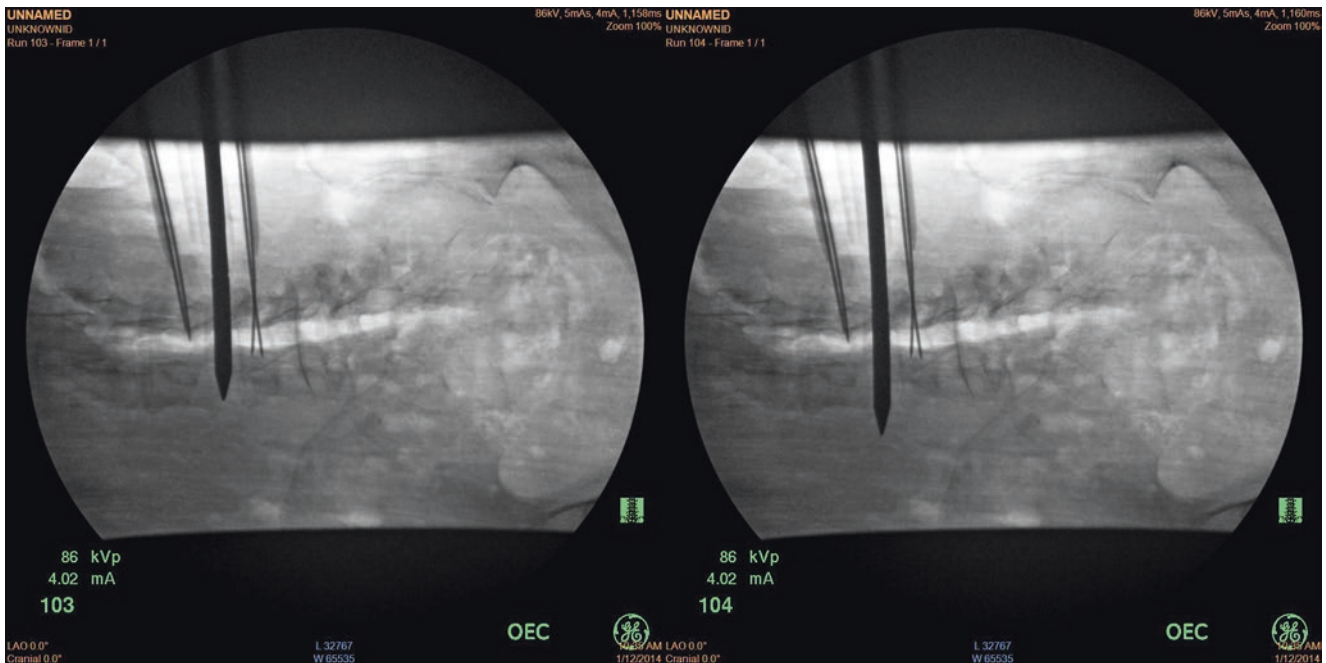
Anteroposterior radiographic image shows intervertebral reamer to the contralateral side
